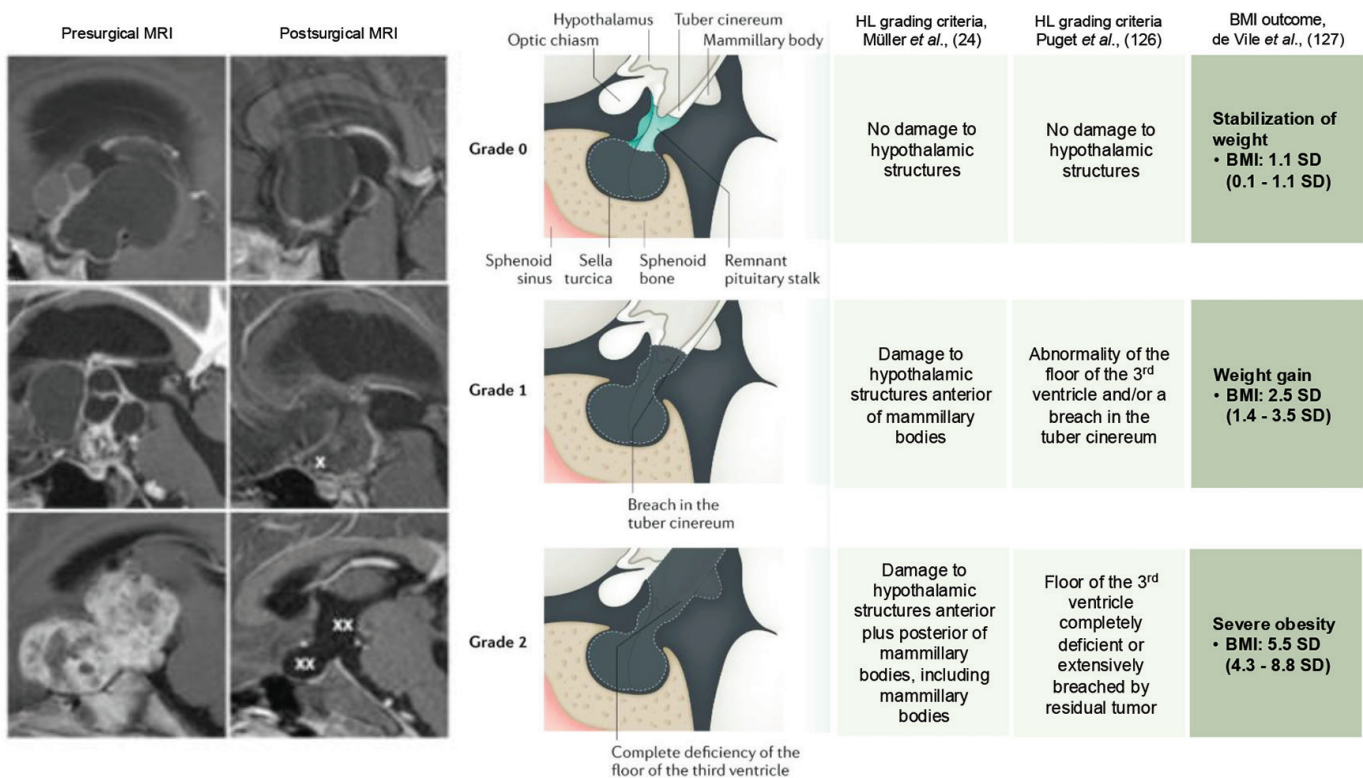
Hypothalamic lesions (HL) in craniopharyngioma: pre- and postoperative grading on MRI and outcome/body mass index (BMI). Definition of different grades of hypothalamic lesions based on postsurgical magnetic resonance imaging (MRI) as published by Puget et al. (126), de Vile et al. (127), and Müller et al. (24). Outcome (BMI) SDS according to de Vile et al. (127) in terms of weight gain and the development of hypothalamic obesity with regard to grade of hypothalamic lesion. Median BMI and interquartile ranges are shown for BMI SDS. X indicates anterior hypothalamic area, XX indicate anterior and posterior hypothalamic area.
